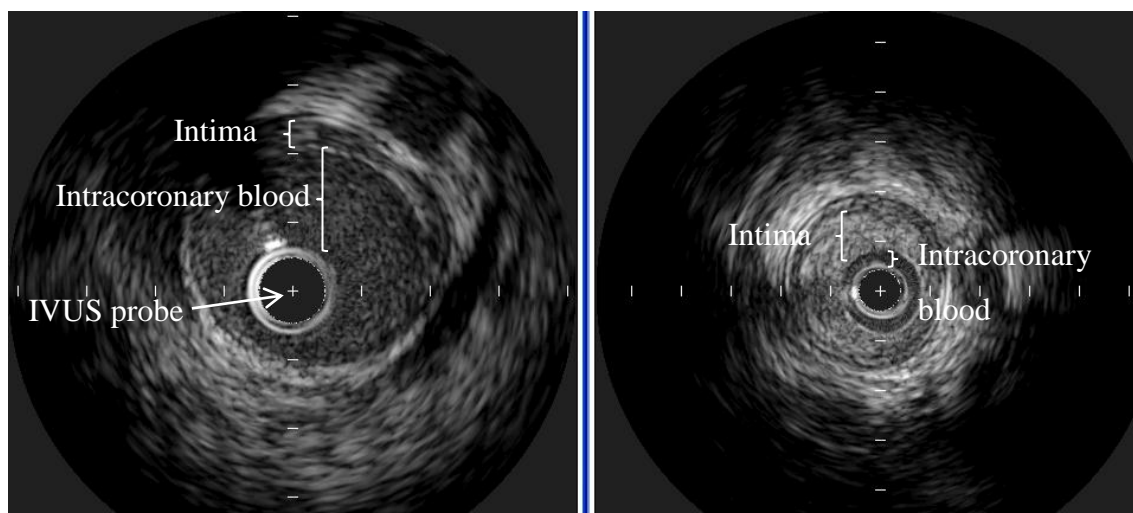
Intravascular ultrasound images of the left anterior descending coronary artery of the same patient taken 1 and 2 years post-transplant. The figure on the left shows a relatively healthy artery, with good lumen size, and only a small amount of intimal thickening in the upper left quadrant. The figure on the right shows the effective lumen now decreased to only slightly larger than the ultrasound probe, with the rest of the artery replaced by grossly thickened intima. The patient had clinically significant CMV disease during the period between the images.
